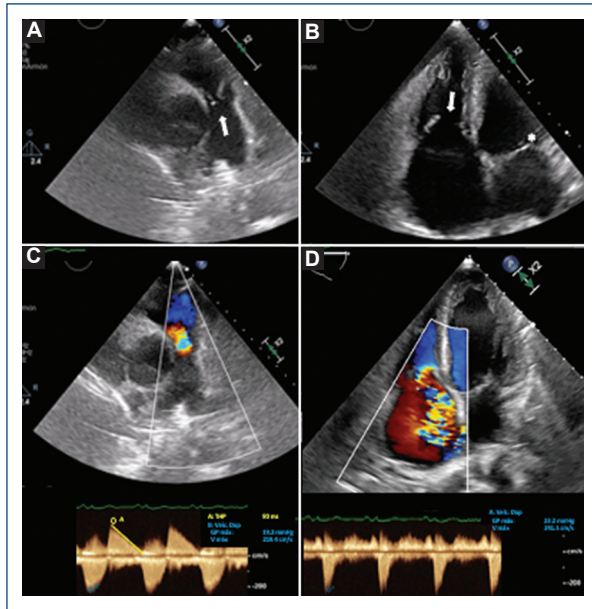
Echocardiogram during admission. A: the short parasternal axis shows the pulmonary valve with thickened and semi-open leaflets in the diastolic phase (cusp separation of 9.9 mm) (arrows). B: the tricuspid valve is seen with thickened and semi-open leaflets in the systolic phase, with a separation of its cusps of 16-17 mm (arrow), while the mitral valve is closed (asterisk). C: using color Doppler, free regurgitant diastolic flow is observed between the right ventricle and the trunk of the pulmonary artery, with 70% occupation of the pulmonary annulus and maximum density pan-diastolic Doppler. The continuous Doppler half-pressure time is 90 ms. The opening of the pulmonary valve is not restricted (slight increase in the maximum systolic velocity of 2.2 m/s, due to the hyperflow component of severe insufficiency). D: in the tricuspid valve, systolic free flow between the right atrium and the ventricle is notable, making it impossible to quantify the regurgitant volume using the PISA method. Continuous Doppler is dense, triangular, with a peak velocity of 2.3 m/s, and it is not suitable for estimating pulmonary pressure. The valve opening is not restricted (peak diastolic velocity < 2 m/s).
